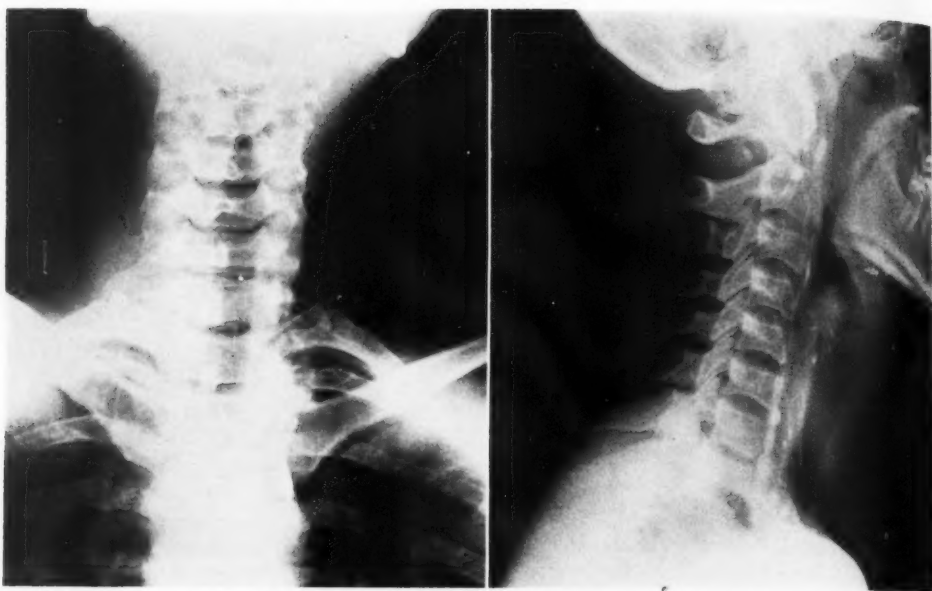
Roentgenograms made following the surgical removal of the left neck mass, showing residual shadows in the left neck. The largest portion of the calcified conglomerate mass has been removed.
